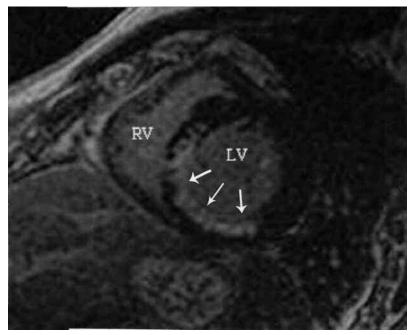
Cardiac MRI, short axis oblique projection of the basal left ventricle (LV), post gadolinium using a prepared inversion recovery gradient echo pulse sequence. There is a well defined area of subendocardial enhancement (arrow) in the territory of the right coronary artery, involving 60-75% of the thickness of the infero-septal wall of the LV consistent with subendocardial infarction. RV: right ventricle.
